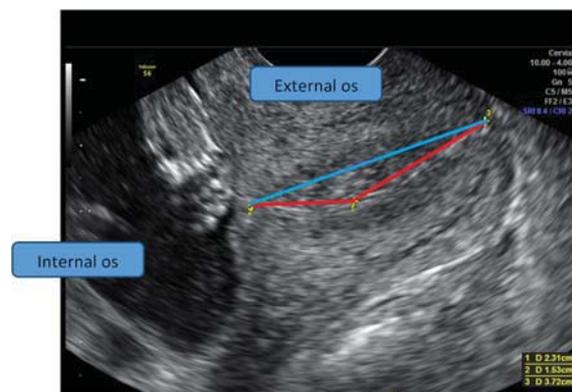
Ultrasound image of transvaginal cervical length in cases of curved cervix.
